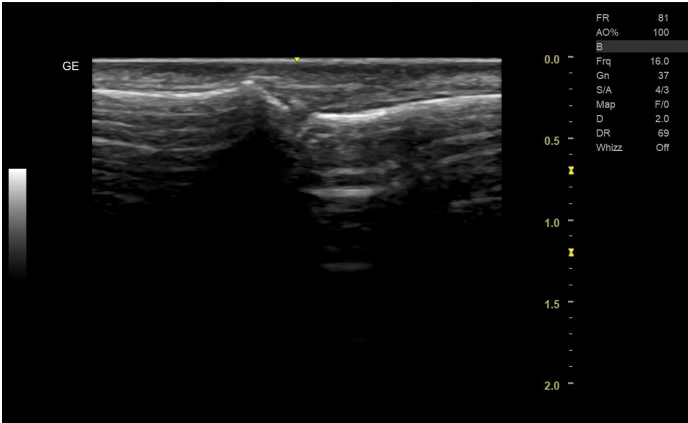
Distorted ultrasound image
